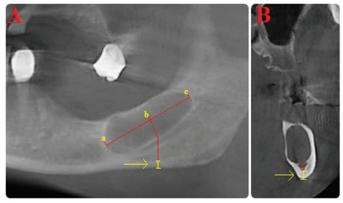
Mandibular posterior intraosseous pathologic lesions (A and B) with cortical borders on reconstructive panoramic images obtained from CBCT
